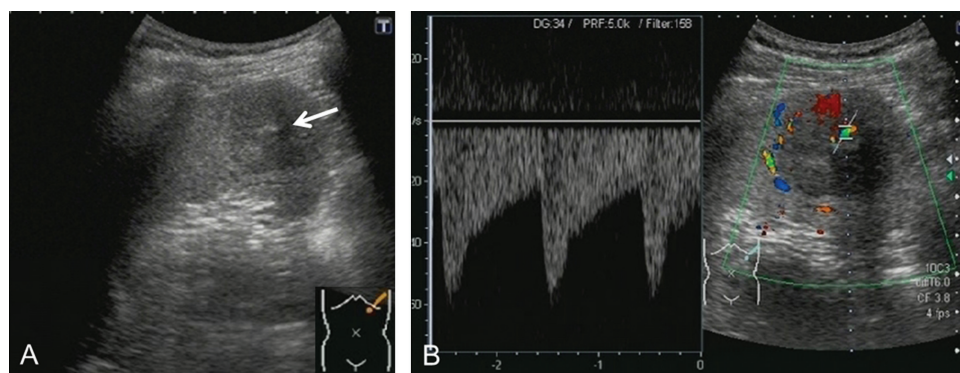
Gray-scale and Doppler ultrasound examination. (A) A left intercostal gray-scale ultrasonography shows a 32×27 mm hypoechoic mass in the lower pole of the spleen with bright linear echoes accompanied by acoustic shadow in the center (arrow). (B) Spectral Doppler analysis shows arterial signals in the center of the mass.
